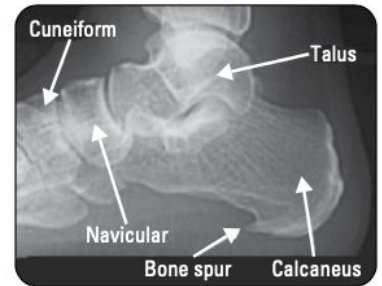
X-ray of bony heel spur
